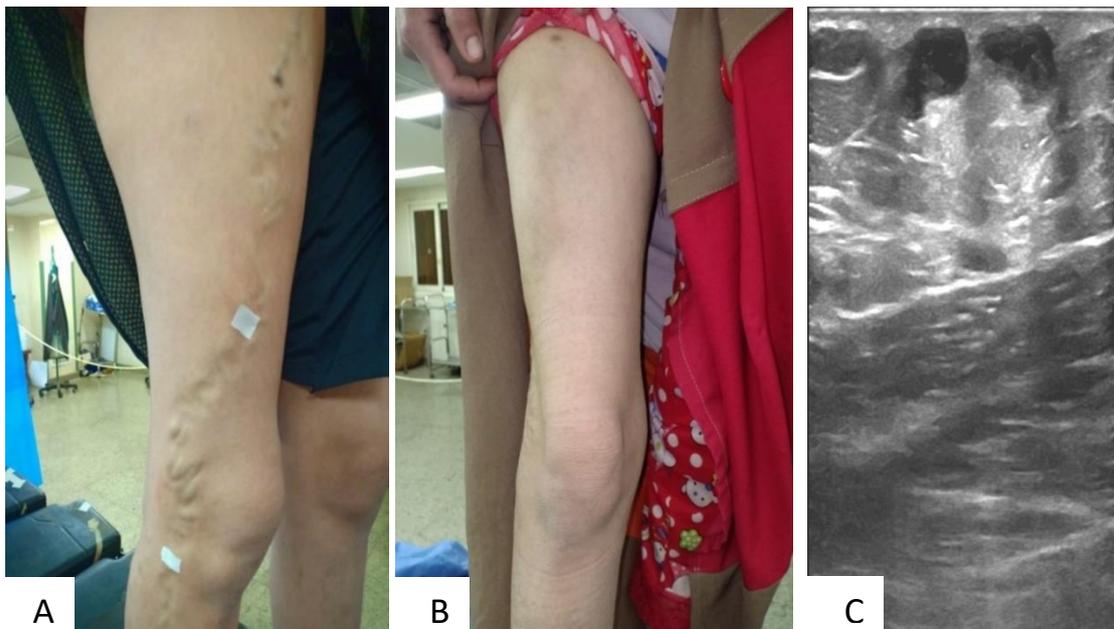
[33] Case no. 2: (A) (B) marked visible varicosities. (C) After three sessions of UGFS, Showing significant improvement. (D) Ultrasound study, the GSV thrombosed and non-compressible with marked reduction in diameter.
